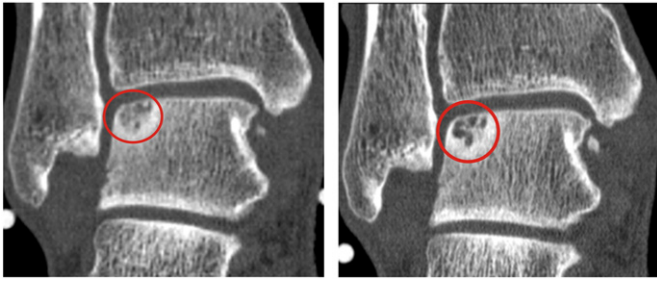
Multiple cystic lesions in the talus, which developed a sclerotic rim. (a) CT image of the talus, coronal view. (b) CT image of the same patient, 11 months later.
